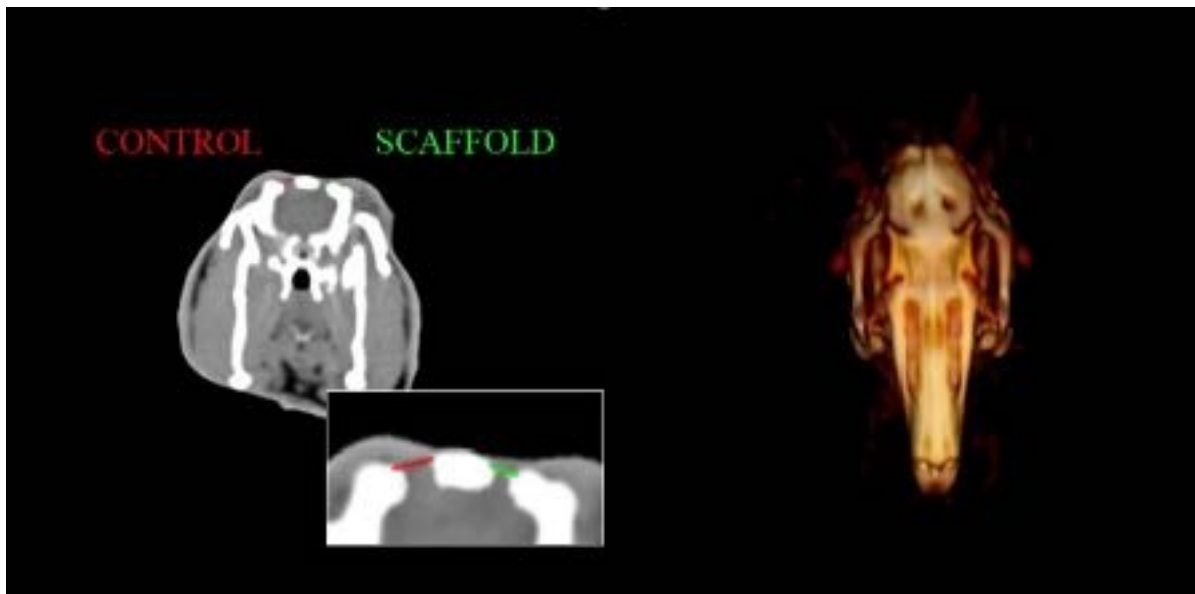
CT scan and 3D reconstruction at 24 weeks. A comparison of the diameters of treated versus untreated bone defects is demonstrated in the coronal view.
